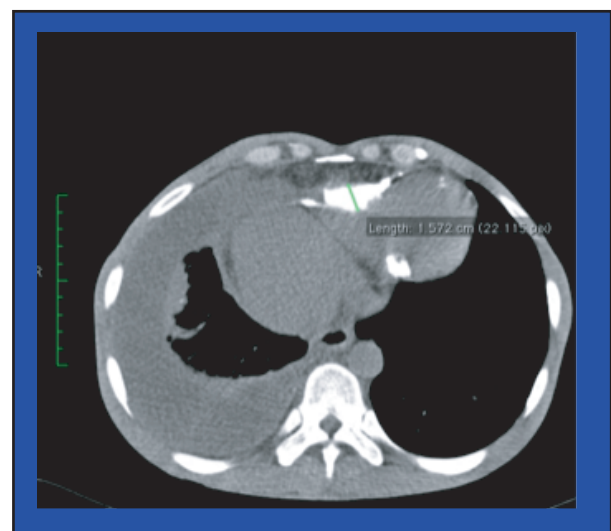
Chest computed tomography, axial view: Calcifications in atrioventricular groove.
